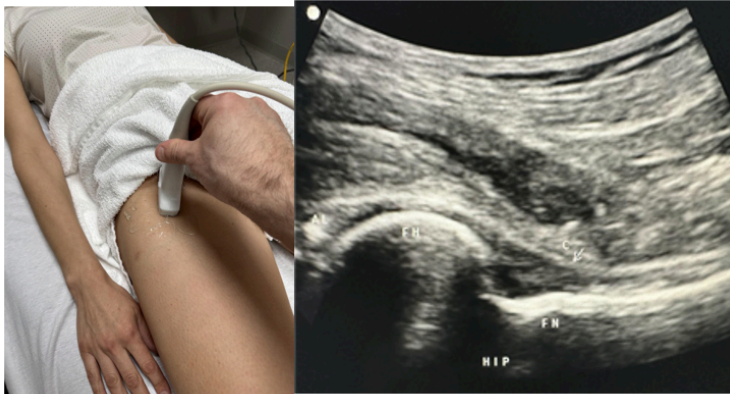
Side-by-side pictures of the transducer position and anterior hip sagittal imaging of the anterior labrum (AL), the femoral head (FH), the femoral neck (FN), and the femoral capsule (C). The abbreviations given here and labeled on the ultrasound image represent the corresponding structures.
